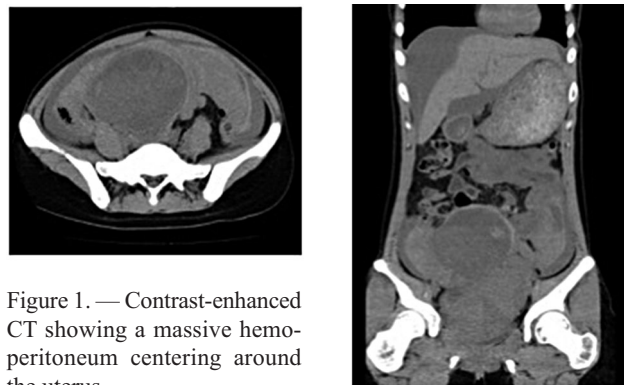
Contrast-enhanced CT showing a massive hemoperitoneum centering around the uterus.
